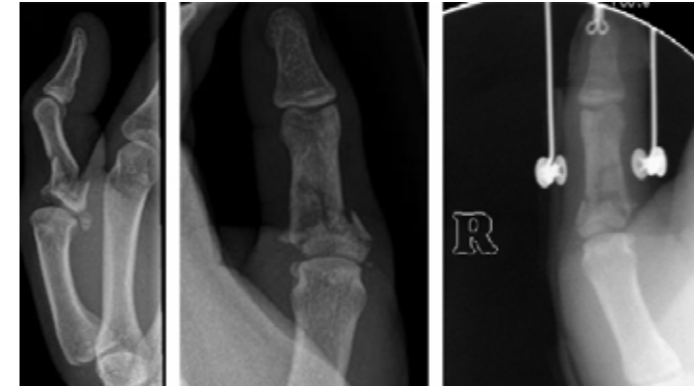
The original fracture, lateral and b) In traction. Full anatomical reduction of the fracture is not always seen on the Xray in traction, however functional ability improved significantly
